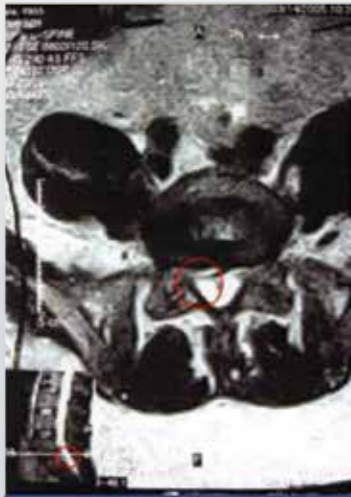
Post-treatment MRI (03/14/05)
